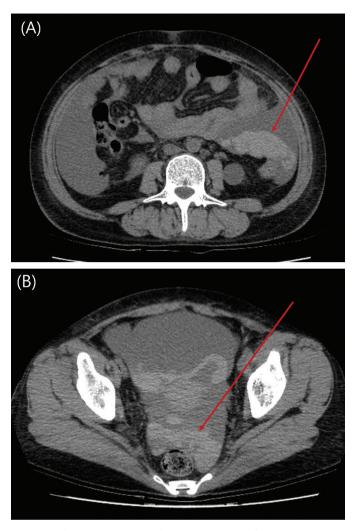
Abdominal pelvis CT scan of patient taken after 29 hours of first CT scan immediately after clinical hypotensive event.
